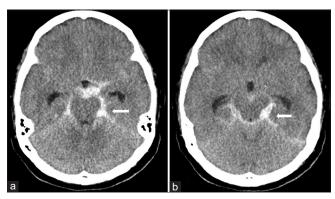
A noncontrast computed tomography scan of the patient's brain revealed diffuse subarachnoid hemorrhage (a) in both Sylvian fissures; the suprasellar, ambient cisterns, and cerebellopontine angle cisterns; and the 3rd and 4th ventricles, especially accumulating in the left ambient cistern (arrows) (b)
